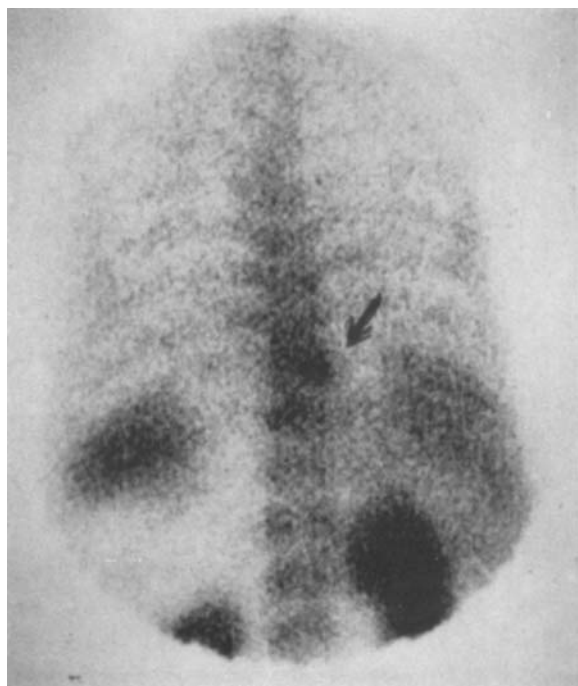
A bone metastasis detected by radioimmunoscintigraphy (BW 431/31) but not by conventional bone scintigraphy.
